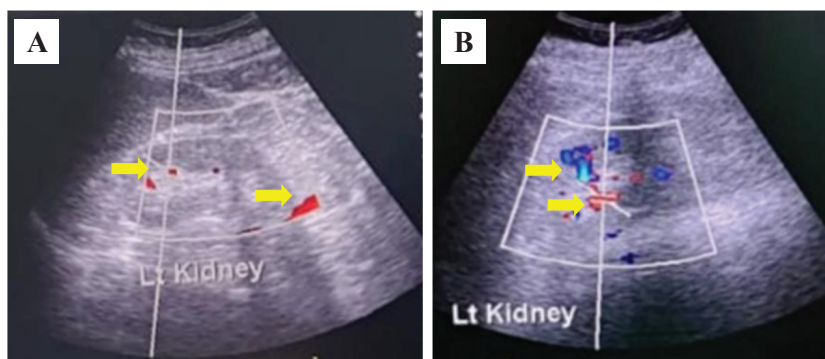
Renal Doppler ultrasonography imaging of a DKD subject. A: before therapy; B: after therapy. The yellow arrow points to the interlobar artery where the hemodynamic measurements were taken. The blue and red colors represent the directional blood flow (venous and arterial, respectively), which appeared to increase in intensity following the administration of DCs, indicating improved renal vascular perfusion.
